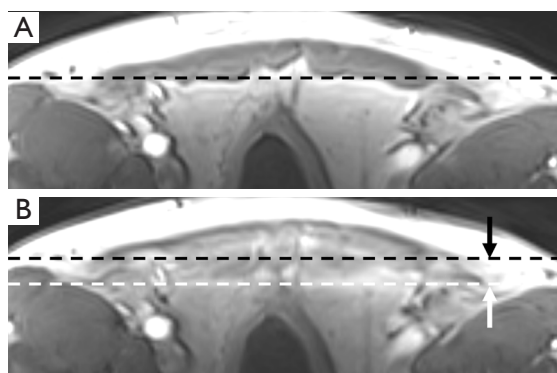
Abdominal wall respiratory motion evaluated on dynamic contrast enhancement MRI shows inspiratory (A) and expiratory (B) excursions. Dashed lines and arrows indicate the outline of the internal wall position in inspiration (A) and expiration (B). MRI, magnetic resonance imaging.
